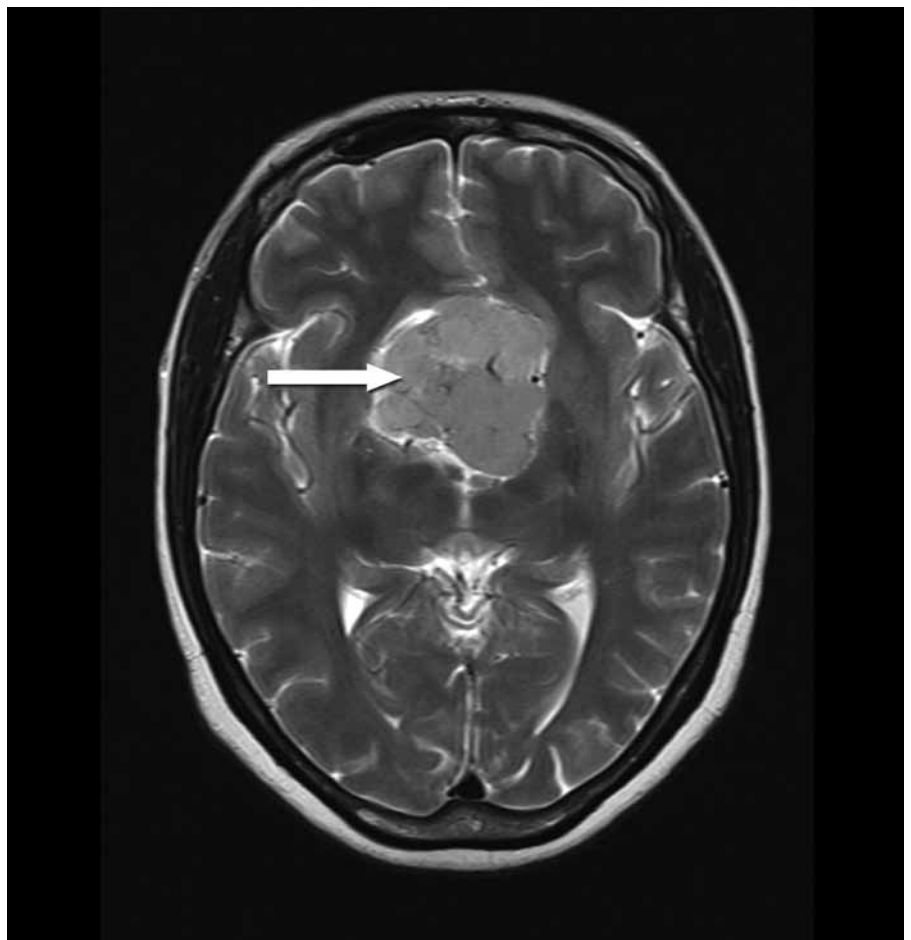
MRI T2 weighted axial view post gadolinium image, showing centrally located mass (white arrow).
